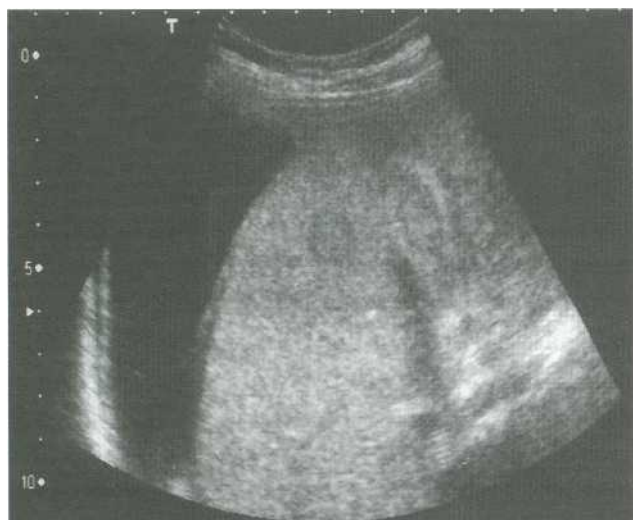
Ultrasonography of liver shows isoechoic nodule (arrow) which has peripheral hypoechoic rim. Ascites is also present
